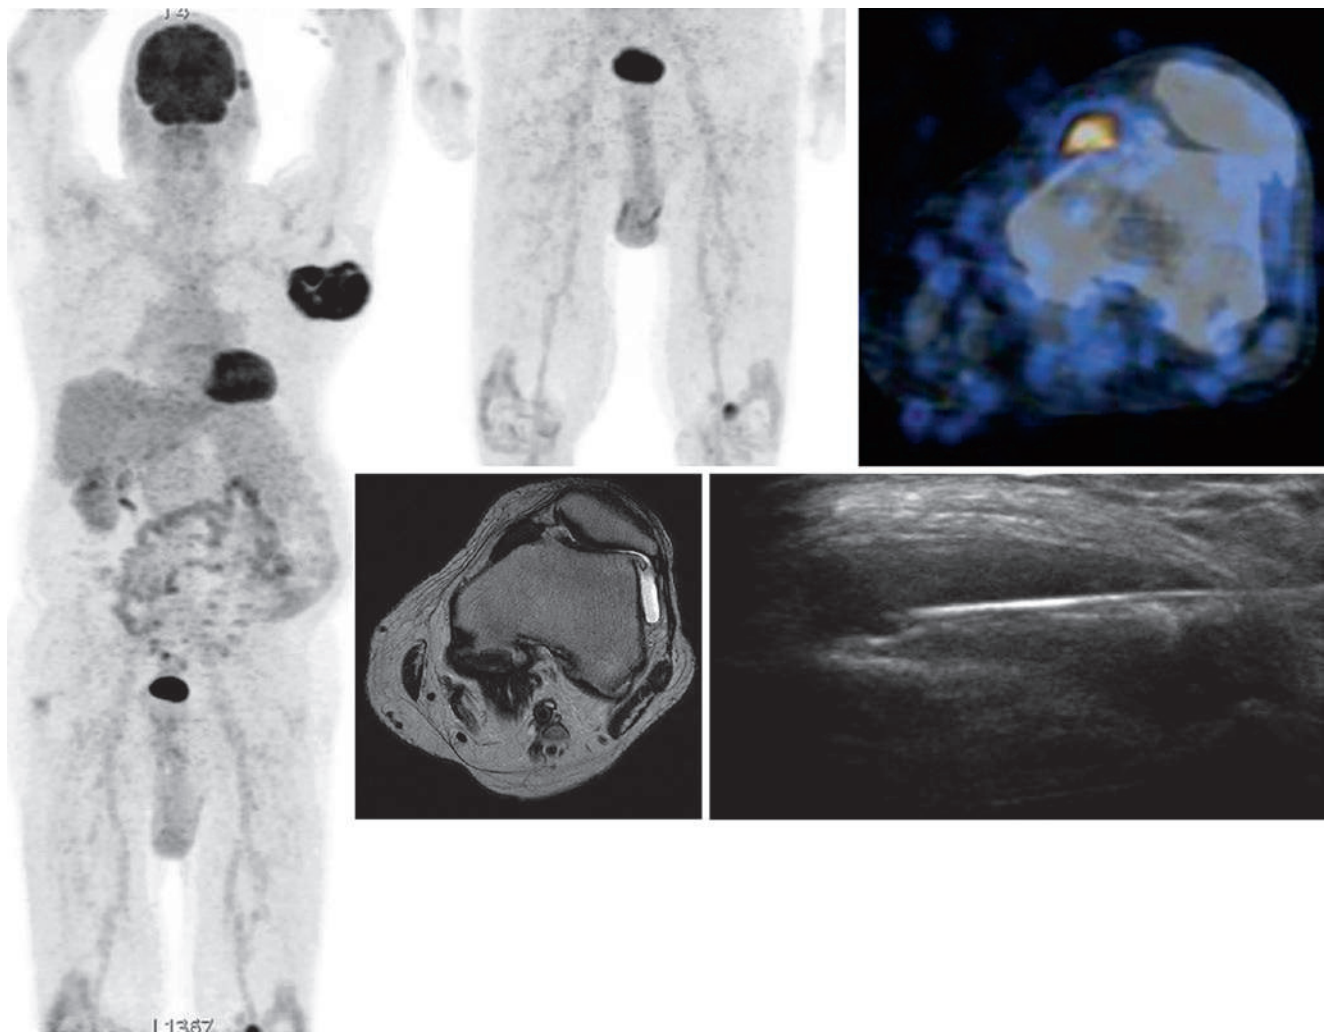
Patient for melanoma staging. Besides a large axillary lymph node metastasis FDG PET/CT shows focal uptake in the left knee. MR and US guided biopsy confirm a benign giant cell tumor of the tendon sheath
